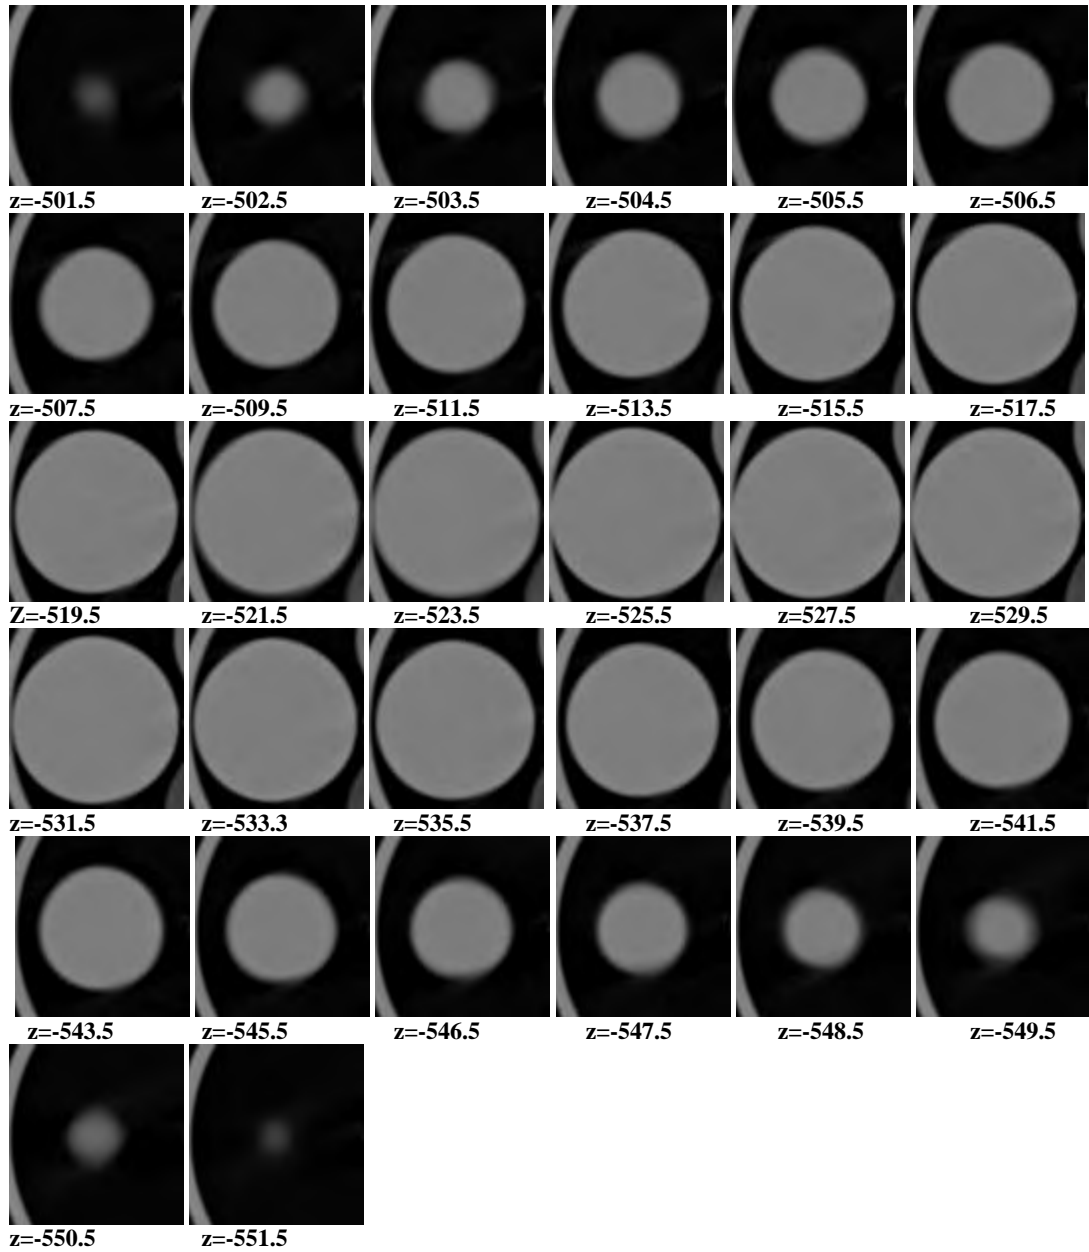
Axial slices of the acrylic sphere (diameter 5 cm) 4D CT scanned while periodically moving transverse to scan plane. Image reconstruction averages over a full gantry rotation (0.5 s) Window level 1200 centred at -600. 15rpm, 120kV, 300mAs 1.5 mm slice, 1 mm reconstruction increment. 50% inspiration.
